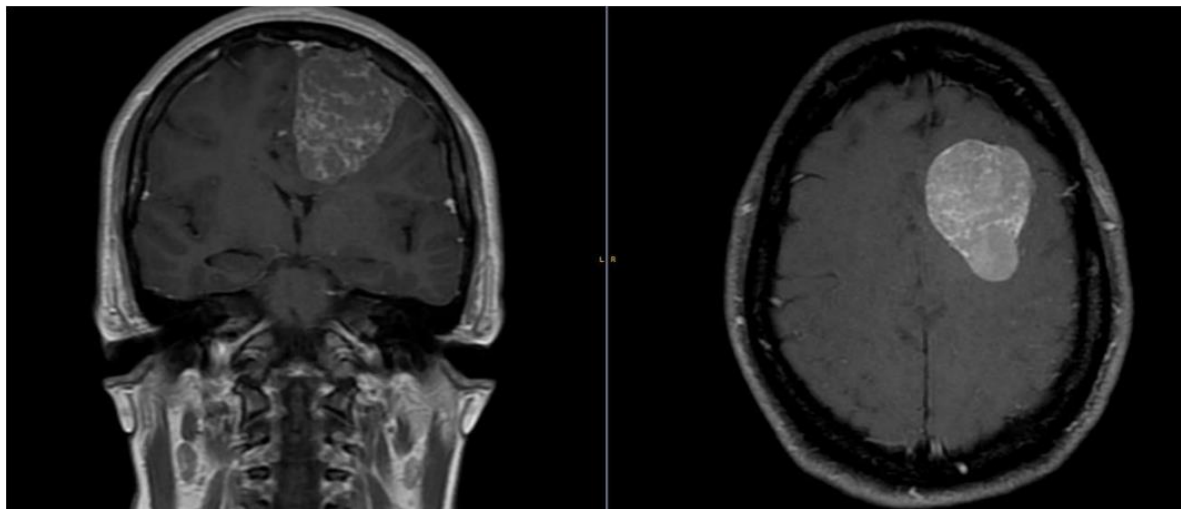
Contrast-enhanced T1 brain MRI in coronal and axial section showing extra-axial lesion in the left frontal region with compressive signs on the adjacent parenchymal associated with vasogenic edema, findings compatible with left frontal meningioma.
